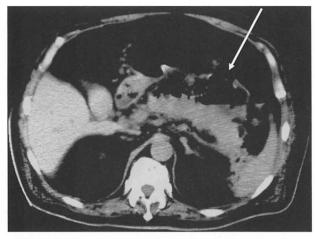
An abdominal CT scan performed 2 weeks after hematochezia showed communication between the abscesses and the transverse colon (arrow), as well as the reduced abscesses.
